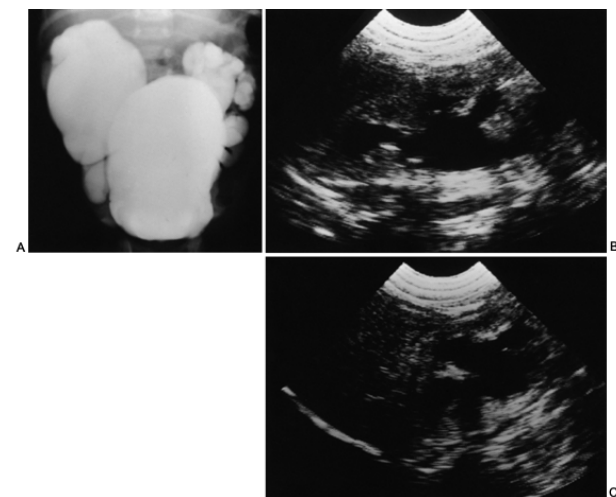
Newborn with distended abdomen and renal insufficiency. A: Voiding cystourethrogram shows huge smooth-walled bladder with bilateral grade V reflux, the typical picture of megacystis-megaureter syndrome. B, C: Following cutaneous vesicostomy, renal function improved, with serum creatinine clearance dropping to 0.7 mg/dL. Ultrasound at 9 months of age shows nicely decompressed upper urinary tracts. Cortex is quite thin. B: Left kidney. C: Right kidney.
